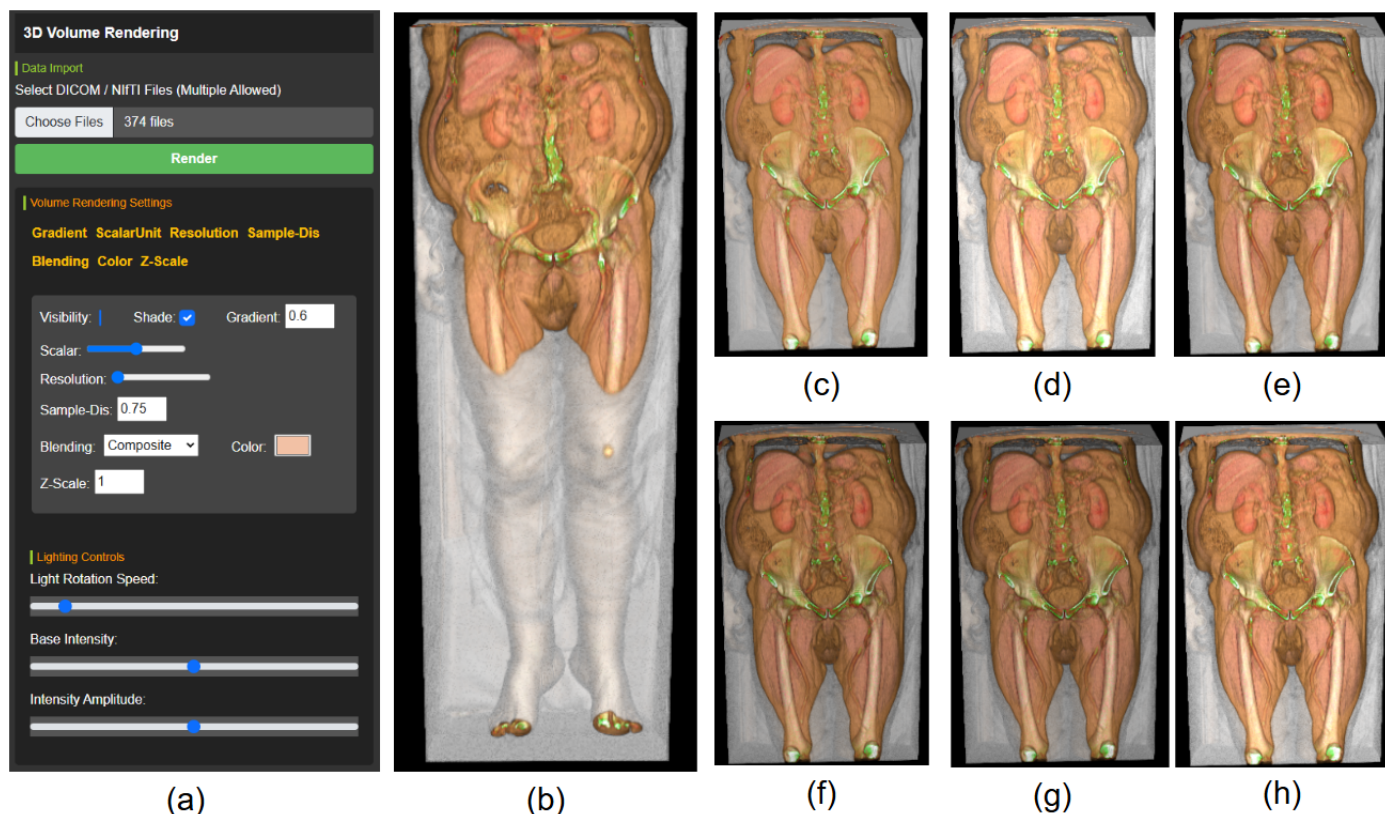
Interactive Visualization of Peripheral Artery CT Imaging for Patient 9 with Dynamic Light Controls; (a) User interface for light control parameters; (b) Full CT volume visualization; (c-e) Region of interest under dynamic light variation; (f) Increased light rotation speed and maximum intensity amplitude; (g) Maximum light rotation speed and intensity amplitude; (h) Static lighting with medium intensity.
